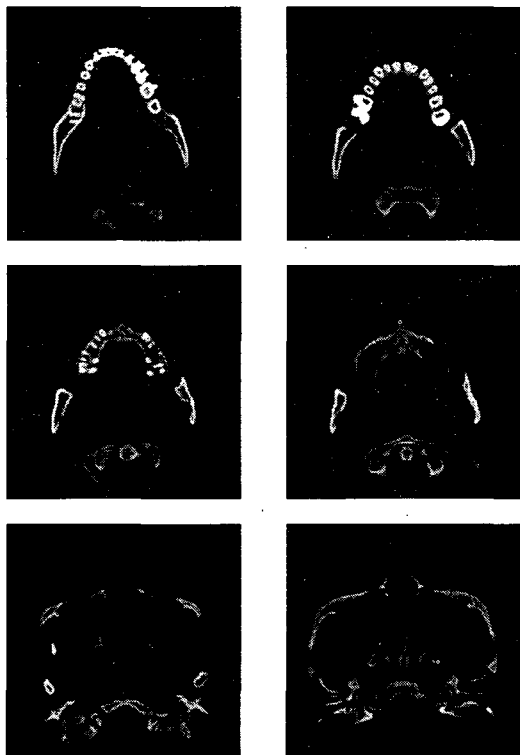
Result of 6 selected axial CT image segmentation
